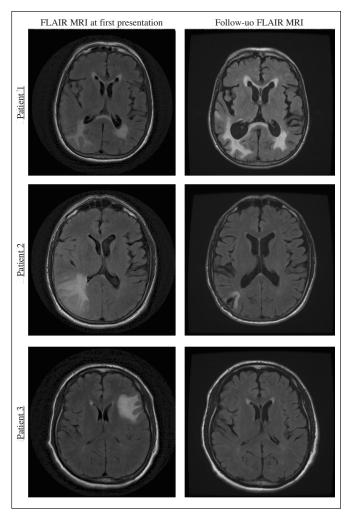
Magnetic resonance imaging (MRI) appearance in patients with ABRA. In Patient 1, the MRI revealed bilateral subcortical T2 hyperintensities and cortical atrophy. Radiographic progression occurred prior to diagnosis (two month interval). In Patients 2 and 3, the focal T2 hyperintense areas noted at presentation largely or completely resolved following treatment.
